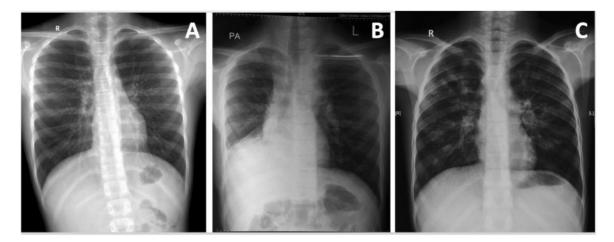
Chest X-rays of three different asthmatic children with ABPA; (A) hyperinflation, (B) collapse of right lower lobe and (C) Bronchiectasis with mucus impaction.
